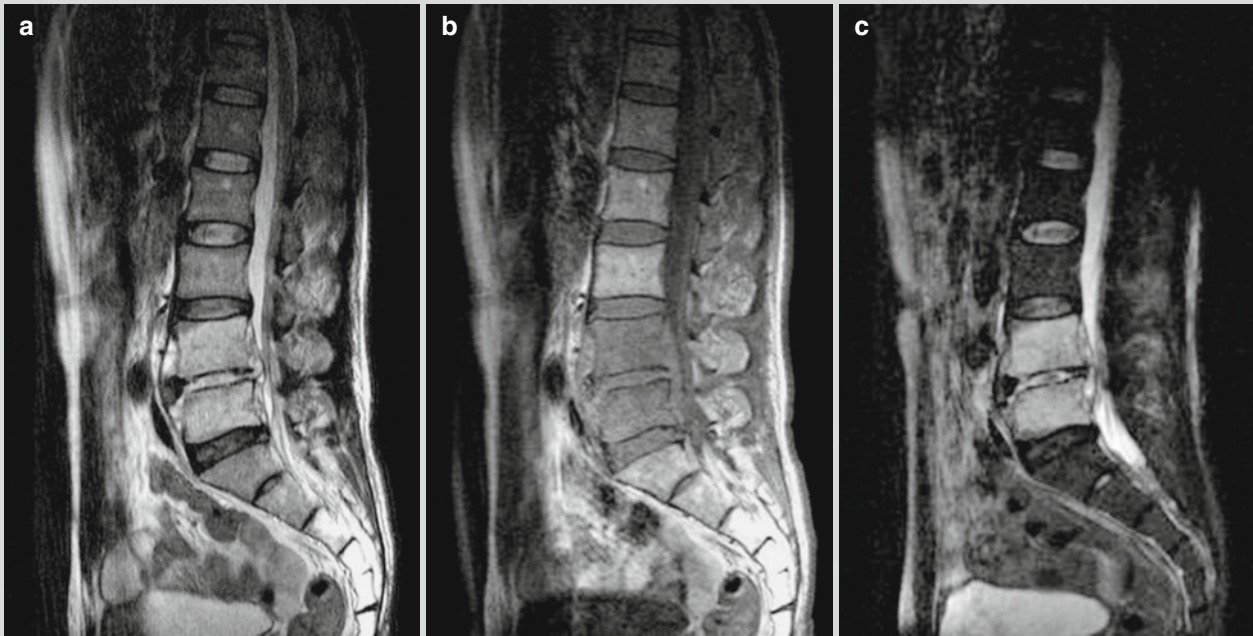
Brucellar spondylitis. (a–c) MR imaging demonstrates slightly deformed L4–L5 with long T1 long T2 signals. By contrast imaging, the whole vertebra is demonstrated with homogeneous
